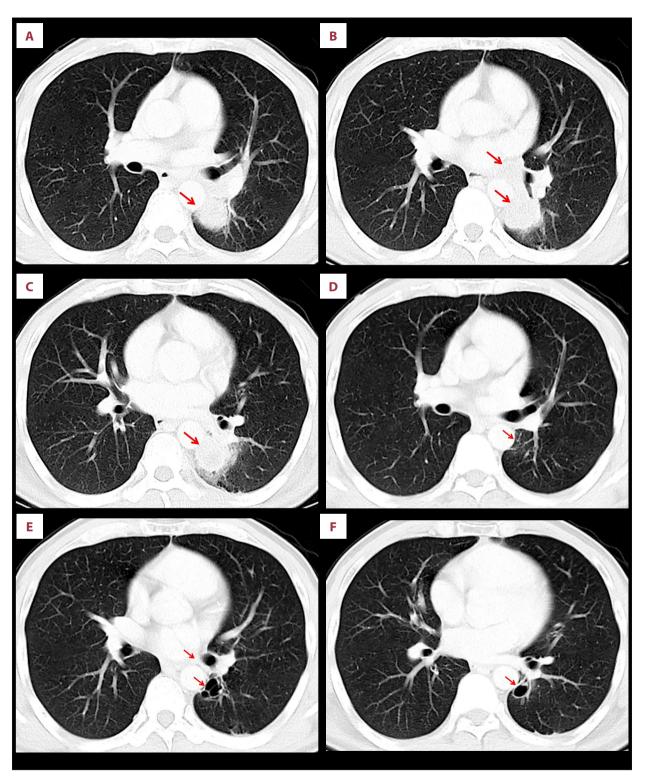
CT images of lung cancer before and after neoadjuvant therapy. (A-C) The CT examination on 2023.05.01 showed a mass (red arrow) in the dorsal segment of the lower lobe of the left lung, involving the bronchus and trunk of the lower lobe of the left lung. (D-F) CT showed that after completing 1 cycle of neoadjuvant chemotherapy and targeted therapy on June 08, 2023.06.08, the tumor completely disappeared and formed cysts (red arrow) and hilar lymph nodes.
